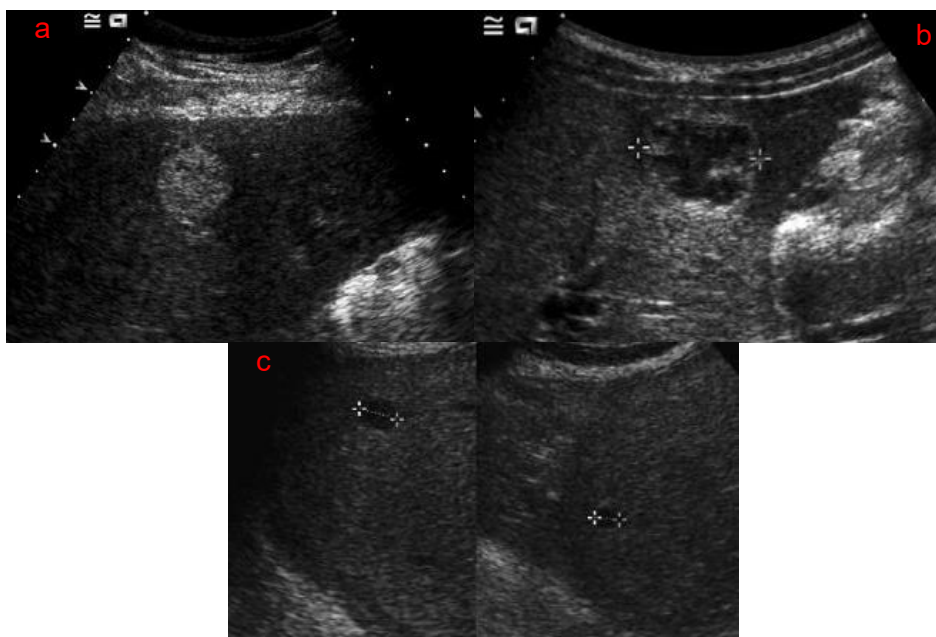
Different examples of metastasis sonographic appearances: a - Hyperechoic with hypoechoic halo; b - Hypoechoic with hyperechoic halo (rare); c - Small hypoechoic lesions.[13]
